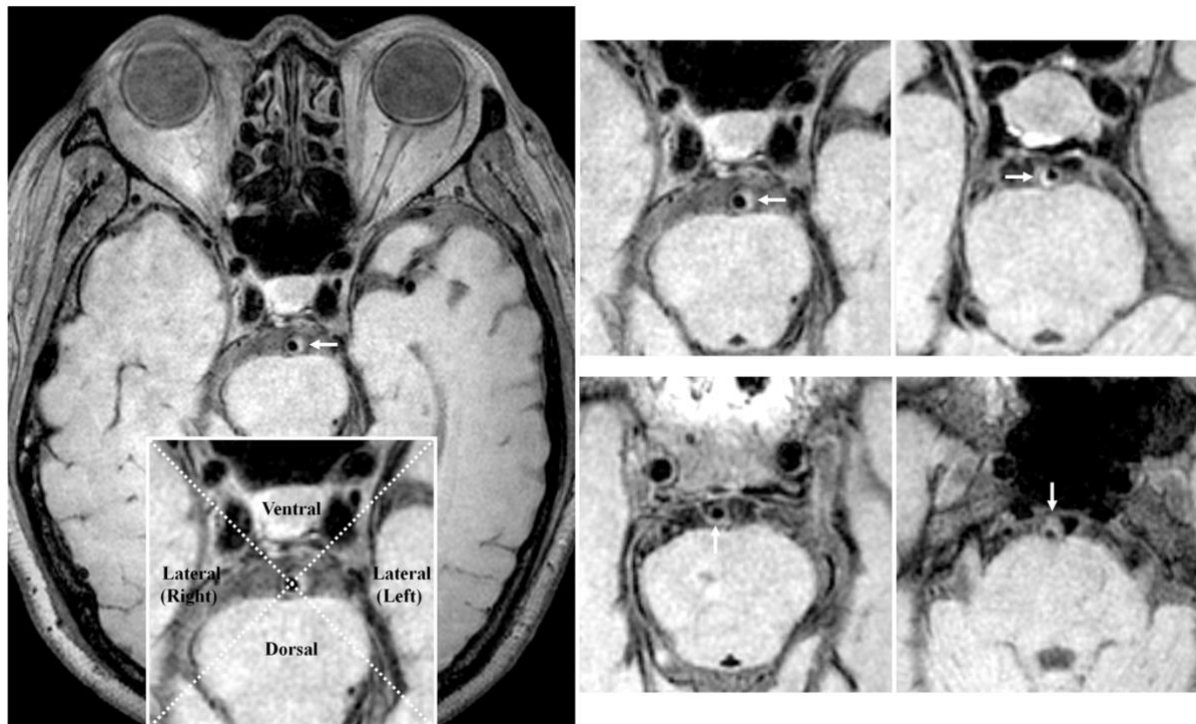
The pattern of the plaque wall distribution in the atherosclerotic BAs is shown on high-resolution vessel wall MRI. The BA atherosclerotic plaque is highlighted in an individual cross-sectional image (white arrow). The BA lumen is centrally intersected by the two dashed lines. Every cross-sectional image of the plaque is divided into four vascular quadrants: ventral, dorsal, right, and left. The plaque in this cross-sectional image may be located on one of the four vascular sides. BA, basilar artery; MRI, magnetic resonance imaging.
